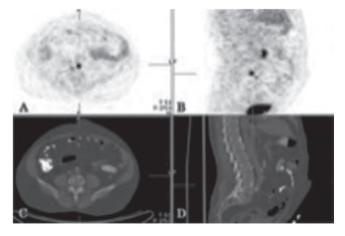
A 62-year-old man with prostate cancer, Gleason score 4+4, who underwent radio theraphy June 2017. Gallium-68 prostate-specific membrane antigen positron emission tomography-computed tomography (68 Ga-PSMA PET/CT) was performed for a persistently raised prostate-specific antigen level (0.47 ng/mL). (A) Axial, (B) Sagittal 68 Ga PSMA PET and (C) Axial, (D) Sagittal CT images showed 68 Ga PSMA-positive sclerotic lesion at the lumbar 4th vertebra corpus (black arrow)
